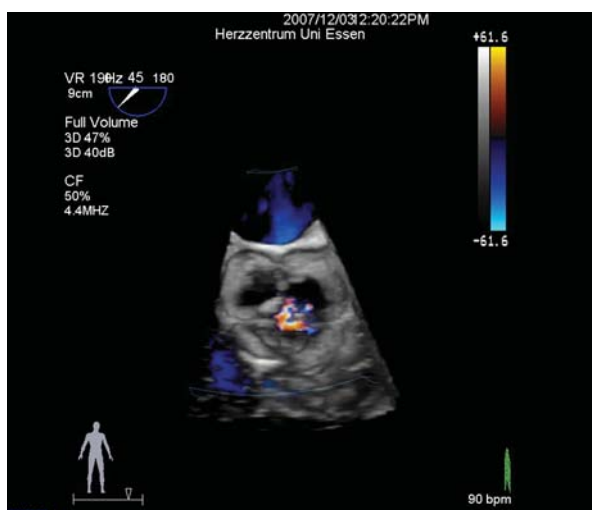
Transesophageal echocardiogram (2-dimensional short-axis view) shows an aortic valve with 4 cusps.
